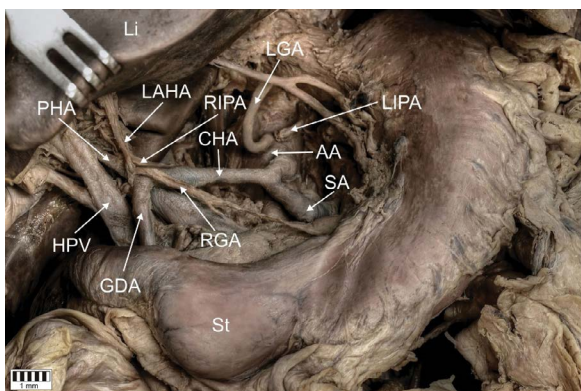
Type 4A — the LIPA originate from the abdominal aorta, and the RIPA originate from the coeliac trunk. PHA — proper hepatic artery; GDA — gastro-duodenal artery; RIPA — right inferior phrenic artery; CHA — common hepatic artery; LGA — left gastric artery; SA — splenic artery; LIPA — left inferior phrenic artery; CT — coeliac trunk; St — stomach; Li — liver; AA — abdominal aorta.
